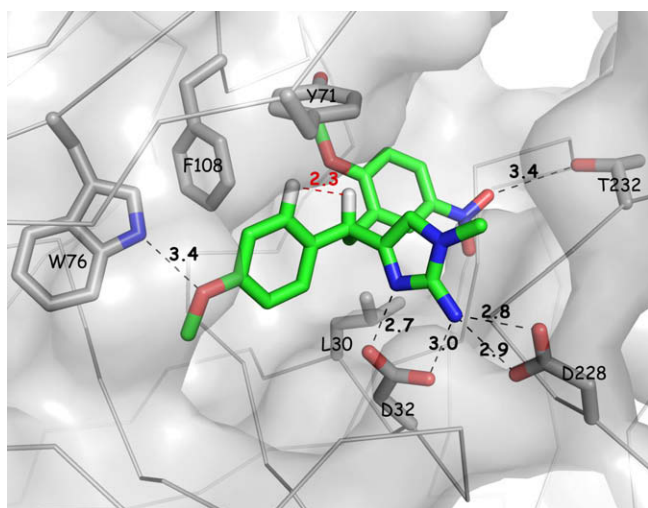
X-ray structure of inhibitor 1 as bound in the BACE-1 active site (PDB ID code: 3H0B). Residues within 3.5 Å of 1 are shown as gray sticks and H-bonding interactions with the inhibitor are labelled. The crucial tertiary carbon hydrogen and the adjacent *ortho* aromatic hydrogen have been added to highlight their alignment and proximity.
